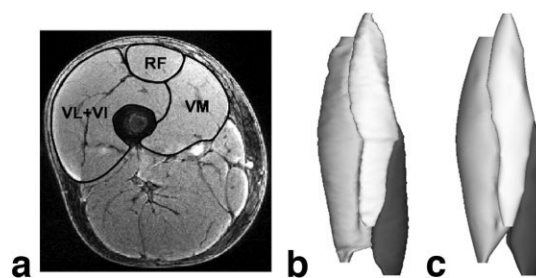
a: Typical example of axial image where *vastus lateralis* and *vastus intermedius* (VL+VI), *rectus femoris* (RF), *vastus medialis* (VM) muscles were manually outlined using the graphical interface developed in our laboratory. b: Typical example of three-dimensional reconstructions of VL+VI (medium shading), RF (light shading) and VM (dark shading) muscles generated with all the outlined slices and used to calculate the MRI reference standard measure of quadriceps volume. c: Typical example of three-dimensional reconstructions of VL+VI (medium shading), RF (light shading), and VM (dark shading) muscles using the Deformation of a Parametric Specific Object method and 7 available slices.
